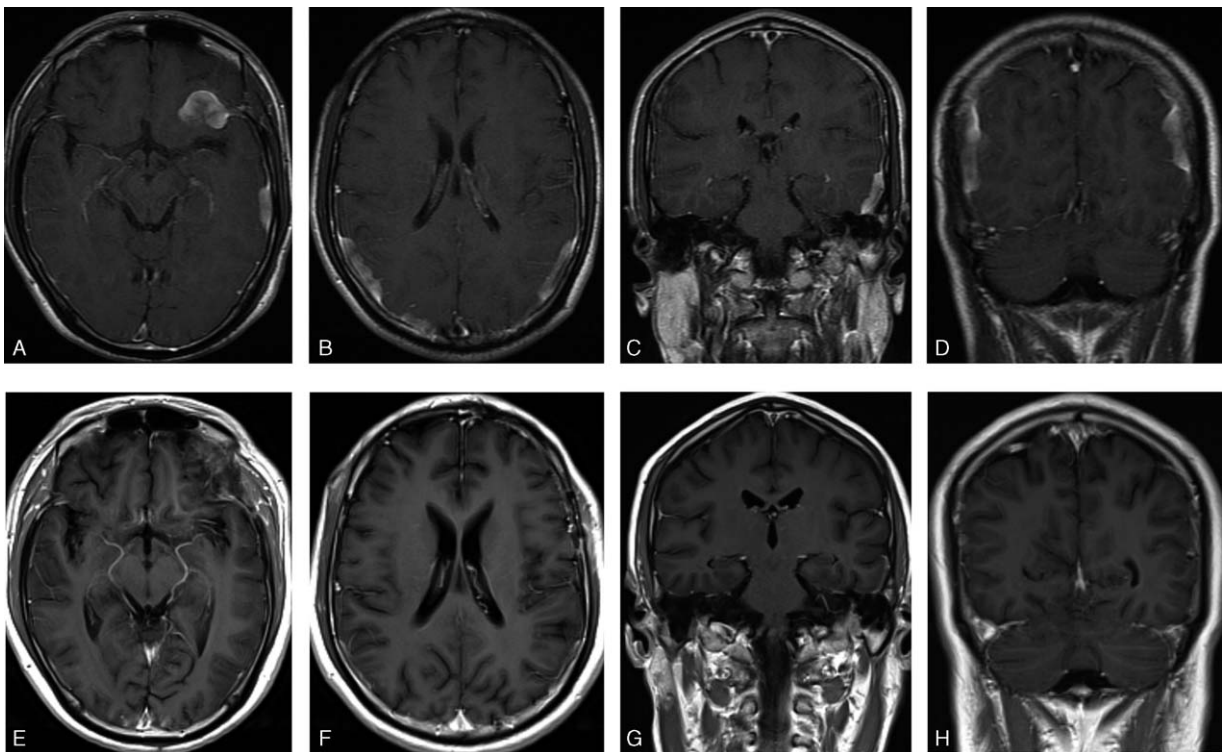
(A–D) Enhanced magnetic resonance imaging (MRI) revealed multifocal enhancement lesions, including left sphenoid wing region, left temporal and bilateral occipitoparietal region; (E–H) serial MRI 4 months later revealed extremely decreasing tumor size.
